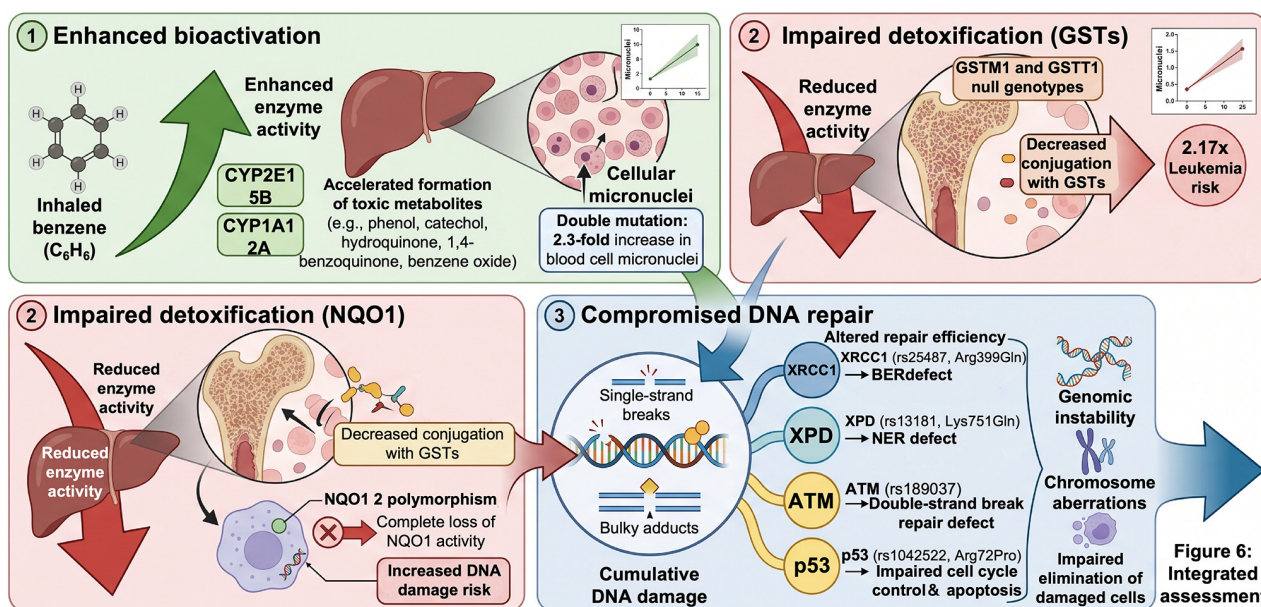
Genetic susceptibility network and multi-gene interactions in benzene-induced toxicity. The individual vulnerability to benzene toxicity is co-amplified by genetic polymorphisms across three critical metabolic and repair pathways: (1) Enhanced bioactivation: Polymorphisms in cytochrome P450 enzymes (CYP2E1*5B, CYP1A1*2A) increase enzymatic activity, accelerating the hepatic formation of reactive metabolites and significantly increasing micronuclei frequencies in blood cells. (2) Impaired detoxification: Null genotypes in glutathione S-transferases (*GSTM1*, *GSTT1*) and polymorphisms in quinone reductase 1 (*NQO12) compromise the clearance of toxic intermediates, with combined *GSTM1*/*GSTT1* deletions synergistically elevating the risk of benzene-related leukemia by 2.17-fold. (3) Compromised DNA repair: Variants in DNA repair and cell cycle control genes (*XRCC1* Arg399Gln, *XPD* Lys751Gln, *ATM* rs189037 and *p53* Arg72Pro) impair single/double-strand break repair and disrupt the apoptosis of damaged cells. Together, these genetic variations drive cumulative DNA damage, genomic instability, and chromosomal aberrations, emphasizing the necessity of integrating multi-gene profiling into comprehensive risk assessments. GSTs, glutathione S-transferases; CYP2E1, cytochrome P450 2E1; CYP1A1, cytochrome P450 family 1 subfamily A member 1; NQO1, NAD(P)H quinone oxidoreductase 1; *GSTM1*, glutathione S-transferase mu 1; *GSTT1*, glutathione S-transferase theta 1; *XRCC1*, X-ray repair cross-complementing protein 1.
